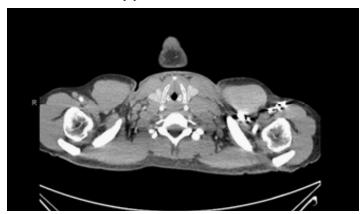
Axial cuts on CT showing submandibular and mediastinal adenopathy. 78x44mm (300 x 300 DPI).
